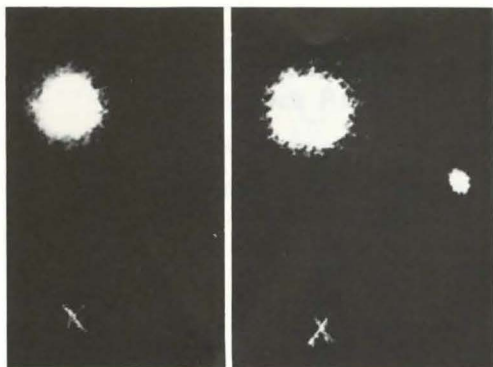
Left: scintigram of the injected bolus of ^{99m}Tc antimony colloid in the tongue base during basal condition. Right: scintigram after taste. Note visualized lymph node far from the main bolus. X: indicates jugulum.
